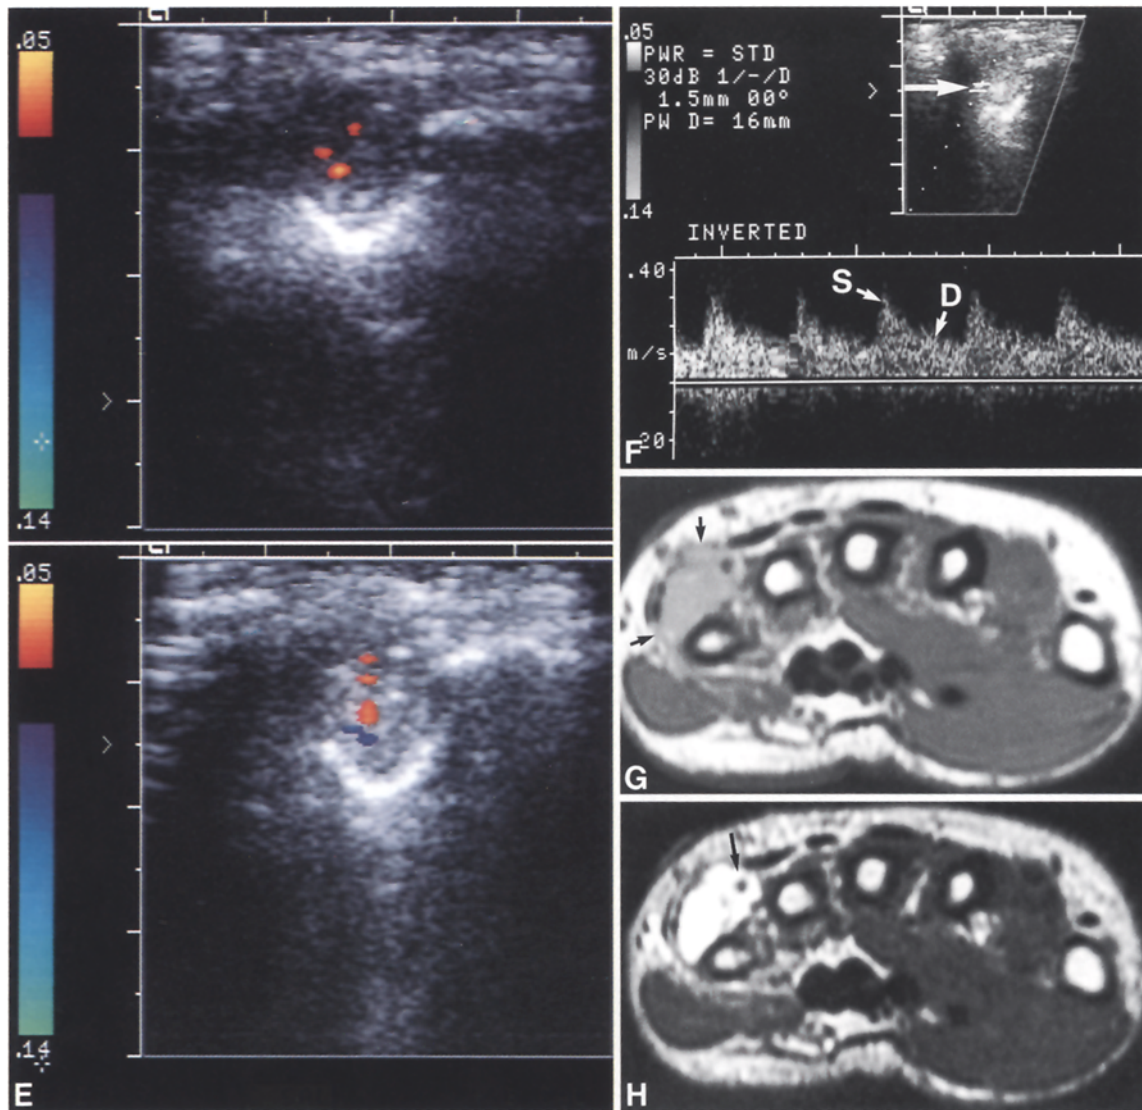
A Plain radiograph of the left hand shows soft-tissue mass situated medially to the base of fifth metacarpal and extending to the carpus (*arrows*). Within eroded bone, three phleboliths are identified. B Coronal CT scan shows soft-tissue mass (*arrows*), bony erosion, and phlebolith. C Axial CT scan shows erosion of hamate (not well appreciated on plain films), dorsal extent of soft-tissue mass, and lack of invasion of subcutaneous tissues. Phleboliths are well demonstrated. D Parasagittal ultrasound scan demonstrates cortex of fifth metacarpal (*C*), interrupted at its base (*curved arrow*) by mass which extends to volar aspect of patient's hand (*open arrow*). E Transverse scan through mass shows colored areas
